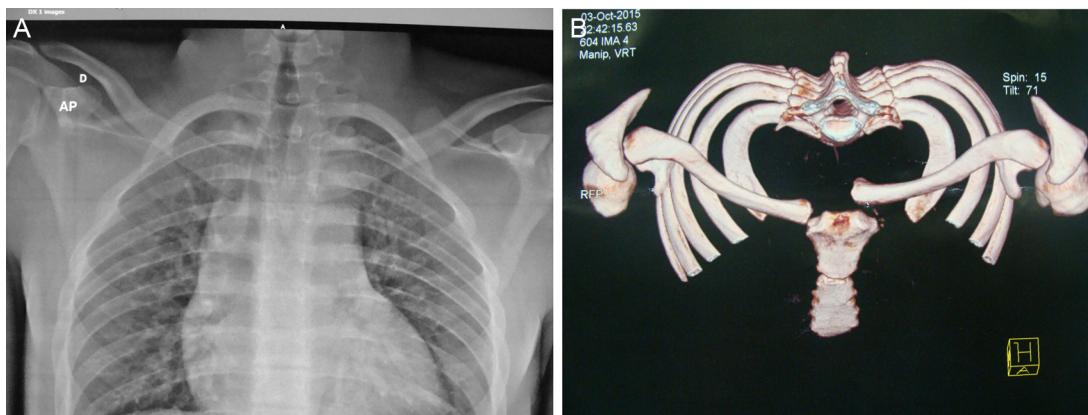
(A) Radiography showing the sternoclavicular dislocation to the left; (B) computed tomography 3-D reconstruction demonstrating the dislocation to the left.
